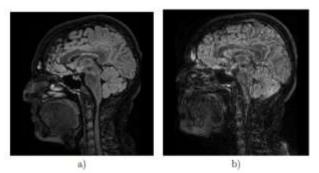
An example of MRI 3D T2 Sag FLAIR CUBE sequence scan for the same subject: a) pre-screaming, b) screaming. Comparing the two, the screaming scan is affected by noise introduced by the subject's movement and head vibration.
